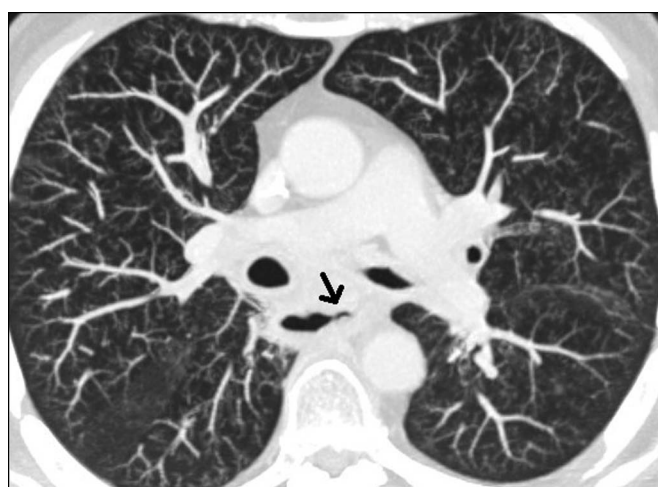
Chest computed tomography with contrast showing a gas-filled tract (arrow) extending from the esophagus toward the left main stem bronchus.
